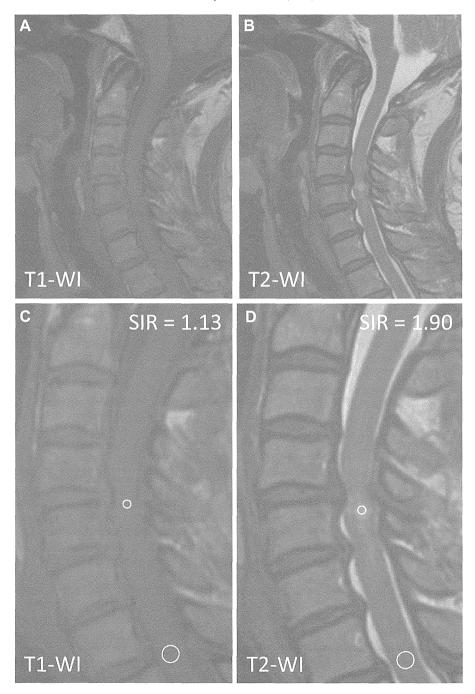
A 54-year-old woman with cervical spondylotic myelopathy showed 66.7% (from 14 to 16) neurologic improvement at follow-up. (A) mid-sagittal T1-weighted MRI, (B) mid-sagittal T2-weighted MRI. Note the increased intramedullary signal intensity at C4–C5 level. (C) SIR is calculated by the mid-sagittal increased cord signal intensity (smaller round) / mid-sagittal normal cord signal intensity at the C7-T1 disc level (larger round) on T1-WI. (D) SIR on T2-WI is calculated using the same equation on the same lesion on T1-WI.MRI, magnetic resonance imaging; SIR, signal intensity ratio; WI, weighted image.
